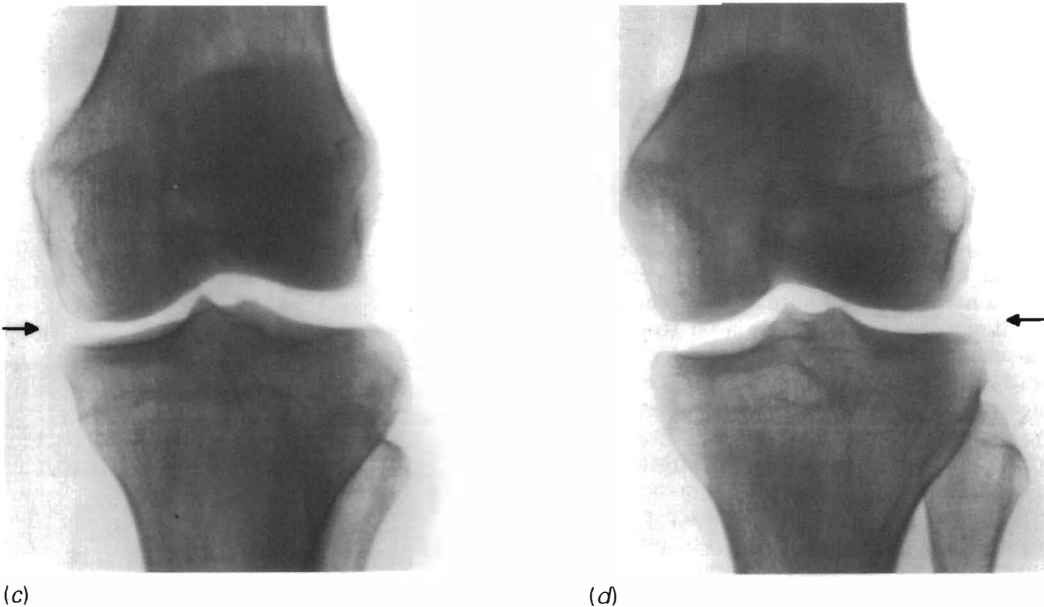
(*a, b*) Distraction of the metacarpophalangeal joint; (*c, d*) medial and lateral gapping of the knee joint, visualized by X-ray
